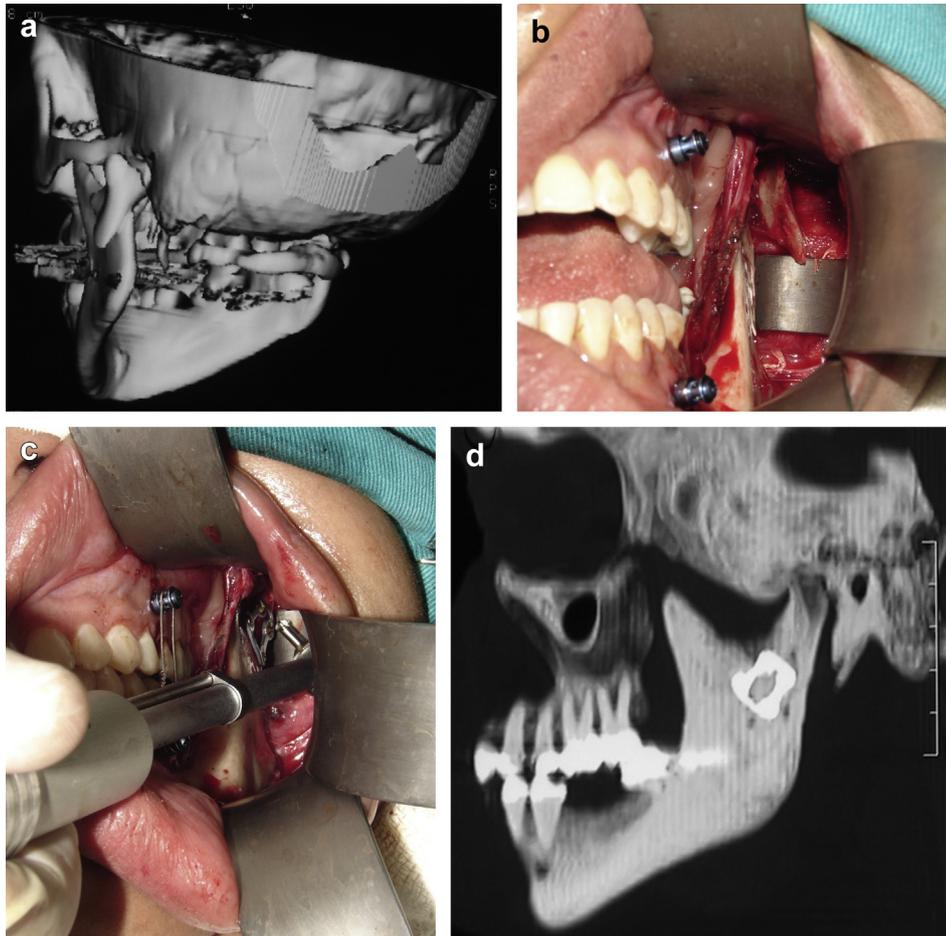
Patient 2. a) Preoperative three-dimensional computed tomographic images showing the left subcondylar fracture with lateral displacement; b) Clinical view of the fracture and use of Bauer and Merrill-Lavasseur retractors; c) A trapezoidal condylar plate was fixed with an angulated screwdriver using an intraoral approach; d) Postoperative computed tomographic image showing satisfactory reduction of the subcondylar fracture.
